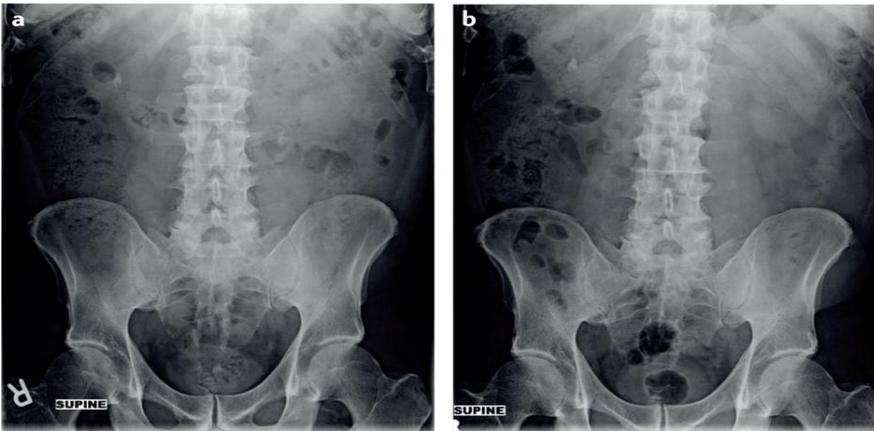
Two plain films of the abdomen before and after treatment for an obstructing left-ureteral stone.
